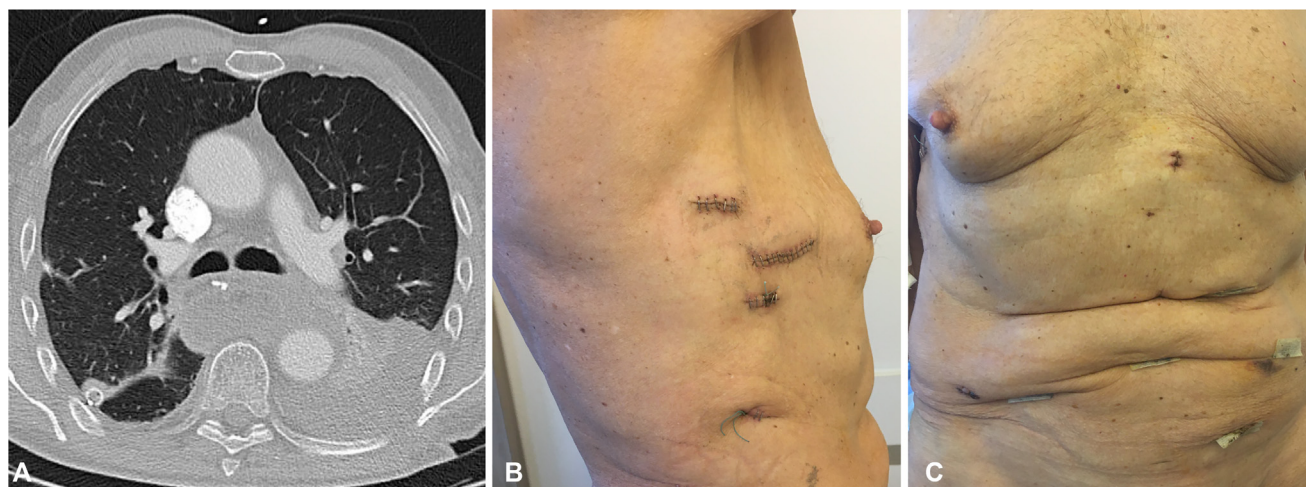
A, Elective postoperative computed tomography scan of the chest on postoperative day 7 without evidence of a bronchial or anastomotic leak. B and C, The patient was mobilized postoperatively and recovered well without further complication such as surgical site infection.
